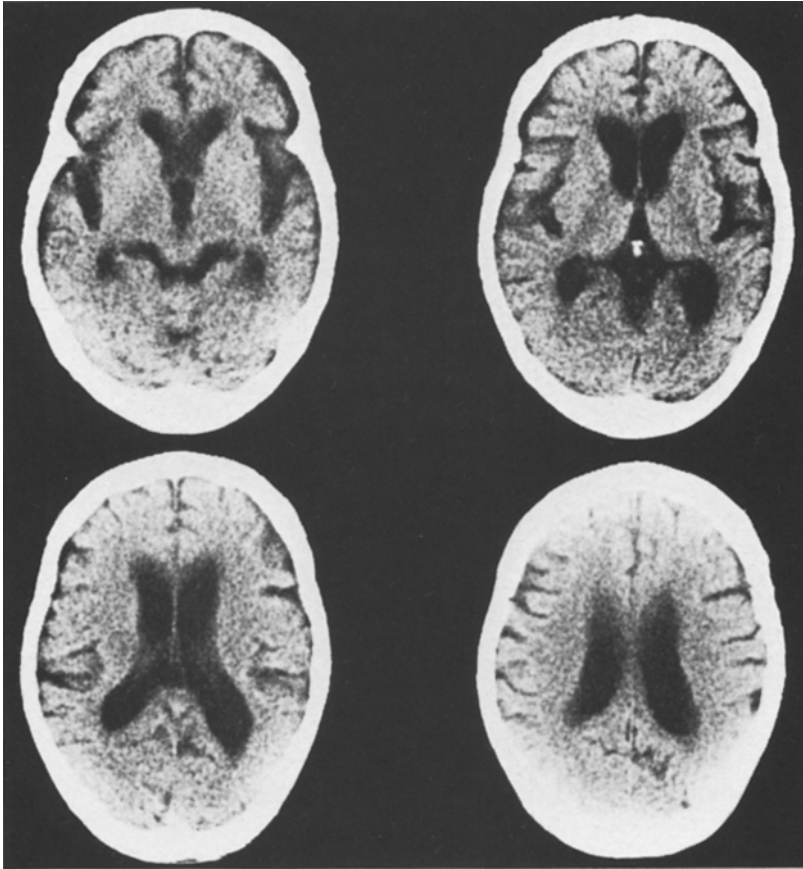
CT of a stage II patient
